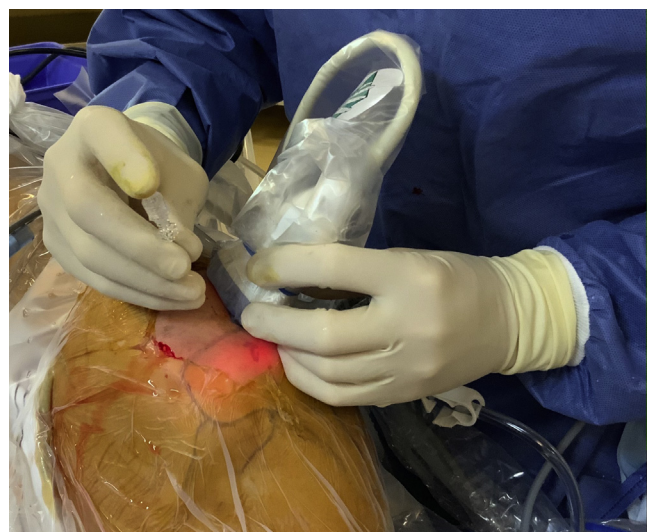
Right shoulder in a 34-year-old female patient in lateral position. Transverse arthroscopic ultrasound-guided needling: placement of a needle perpendicular to the main axis of the probe.
